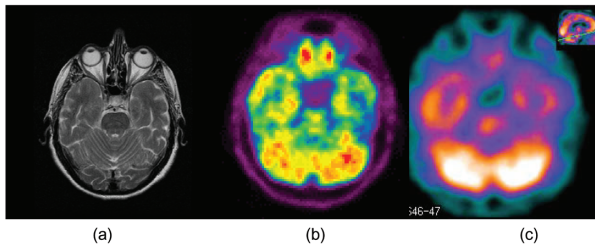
Imaging in patient 5 with primary progressive atrophy. (a) Magnetic resonance image showing no aphasia. Temporal hypoperfusion and hypometabolism revealed on (b) PET and (c) SPECT.
